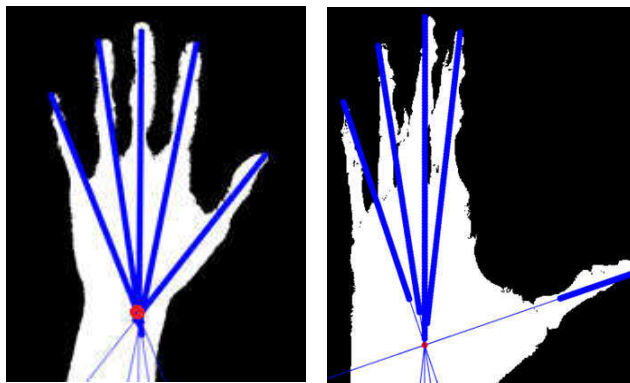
Enumerating fingers in abnormal hand radiographs using skeleton function from a gravity point to tip of each fingers coordinates values. (a) represents the original abnormal x-ray radiograph (b) shows the preprocessed version of abnormal x-ray radiograph (c) shows the segregation of the unwanted regions such as labels and borders and obtained ROI (d) represents skeletonization algorithm that selects the gravity point of the hand and directs the diverse branches for the abnormal hand.
